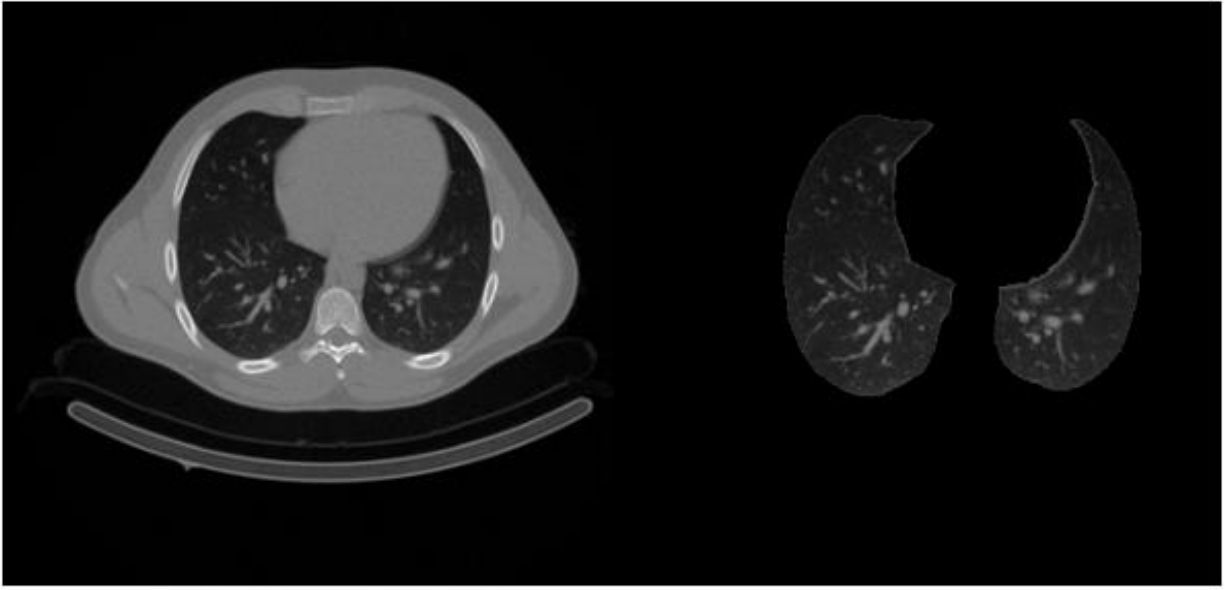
CT, and mask processing
